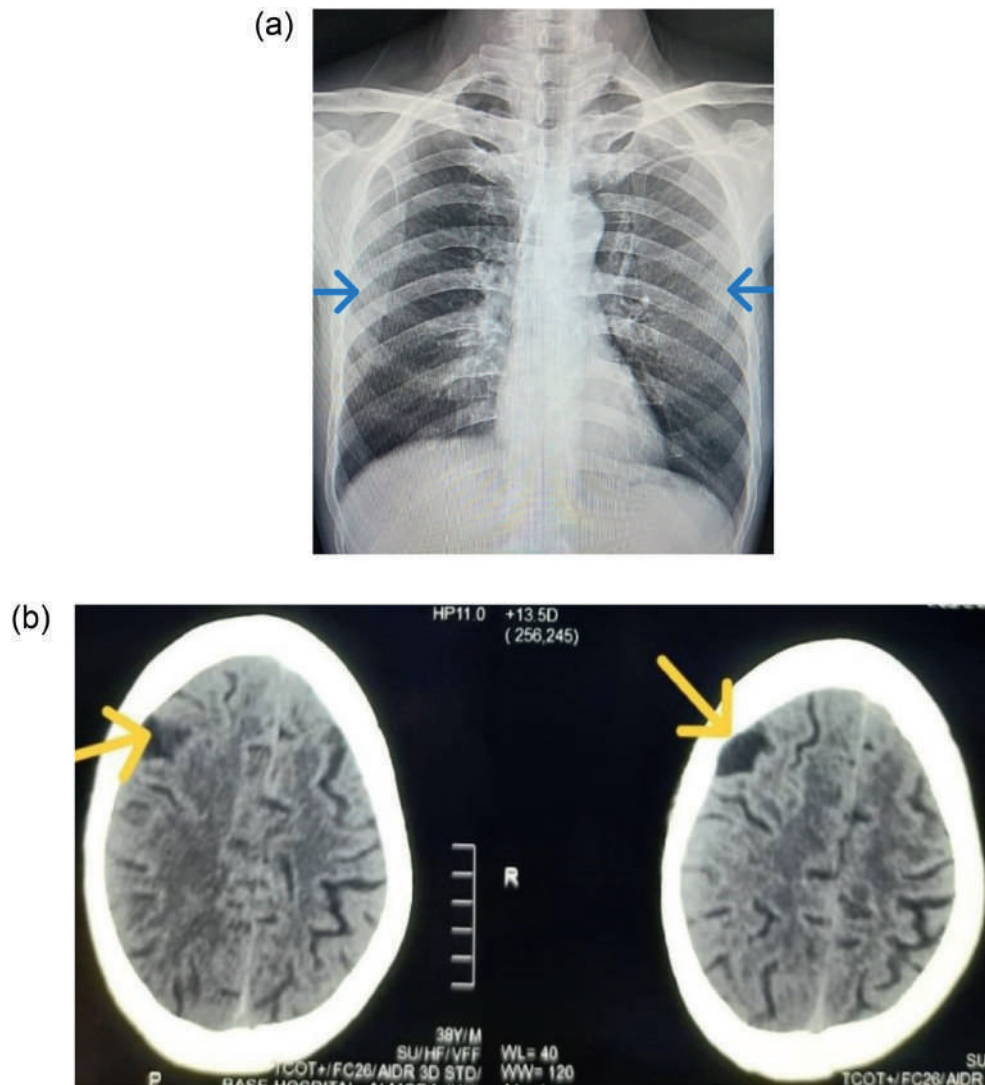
(a): Arrowheads showing a normal chest radiograph
